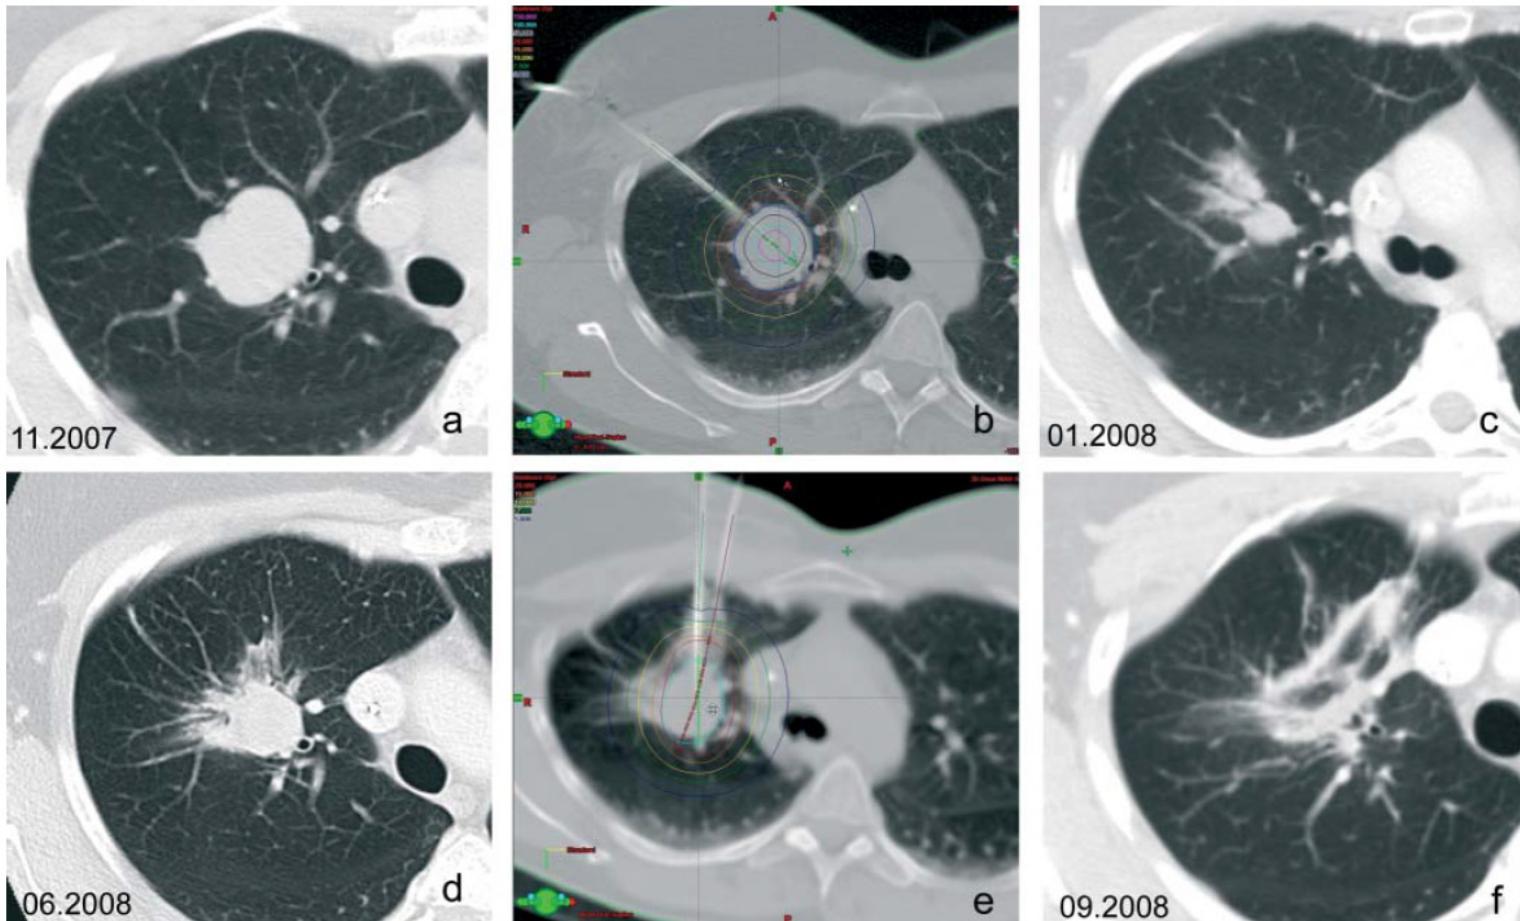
46 Jahre alte Frau mit einer Lungenmetastase eines myxoiden Lipsarkoms. a zeigt den Ausgangsbefund der 4,2 cm großen Metastase. Nach Therapie mittels Afterloading (20 Gy tumorumschließend) zeigt sich eine deutliche Größenregredienz b. 7 Monate später trat ein lokaler Progress der Metastase auf c, welcher durch erneute Ablation mit CT-HDRBT erfolgreich behandelt wurde [23].
